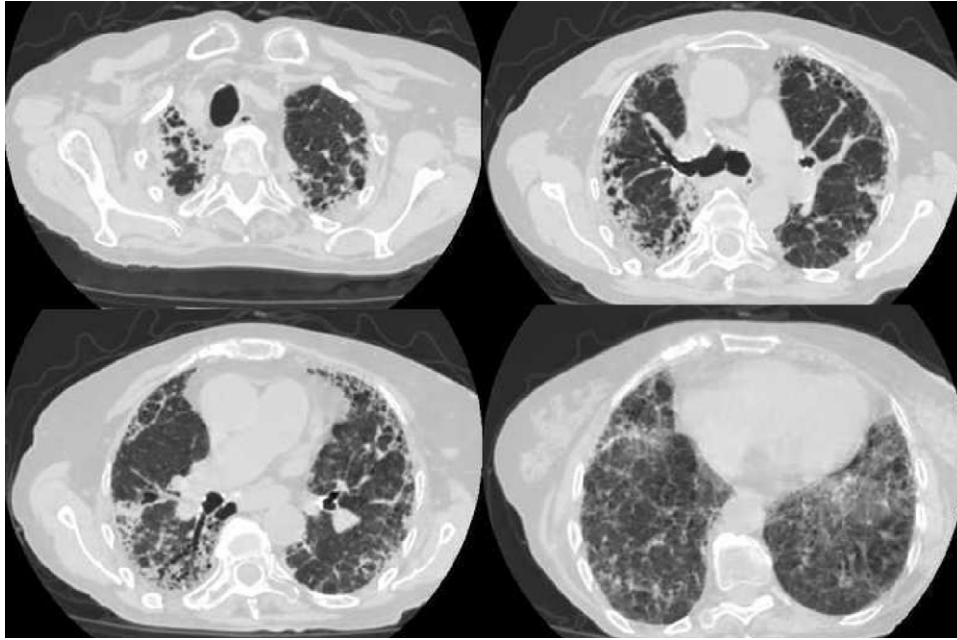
HRCT showing diffuse reticular fibrosis with peripheral honeycombing.
